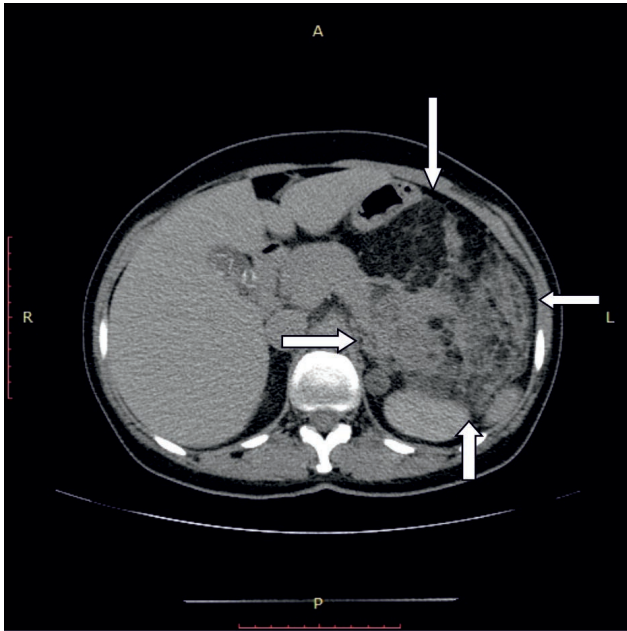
Computed tomography scan showing giant pathological mass in left kidney measuring 141 x 100 x 168 mm.
